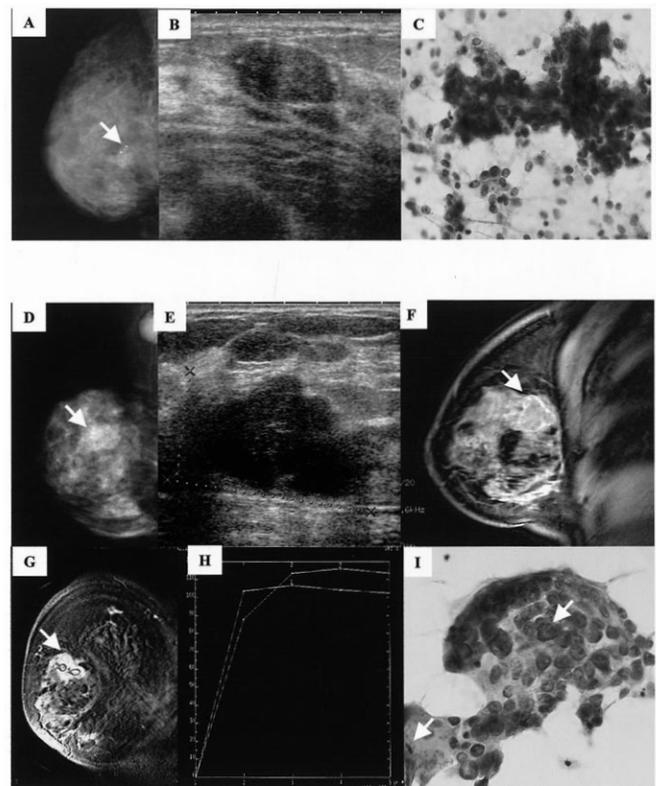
Typical pictures of fibroadenoma (A, B and C) and invasive ductal carcinoma (solid-tubular) (C, D, E, F, G, H and I). A. Mammography reveals a mass with coarse calcifications (arrow). B. Ultrasonography shows an oval and hypoechoic mass. C. The papillary cell cluster shows nuclear overlapping and mild enlargement of nuclei. There are many degenerated naked nuclei in the background ($\times 400$). D. Mammography reveals focal asymmetry lesion without calcifications (arrow). E. Markedly hypoechoic, irregular, un-circumscribed mass by ultrasonography. F. MR imaging sagittal view. G. MR imaging coronal view. H. Time intensity curve. I. The cell cluster shows large nuclei with evident difference in size, highly increased nuclear chromatin and large nucleoli. There are two mitoses (arrows) ($\times 400$).
